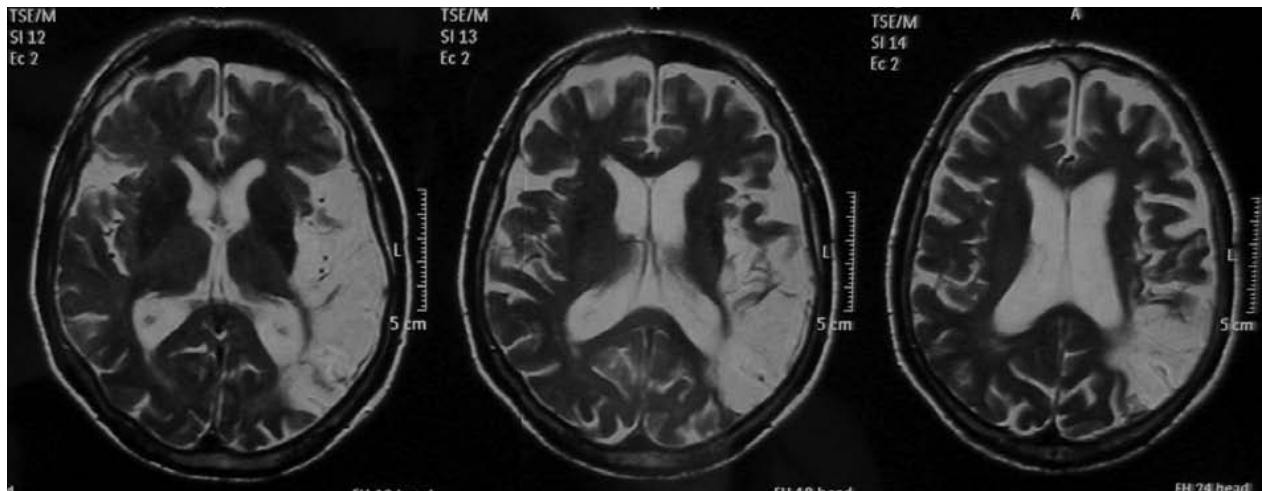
Samples of MRI.
